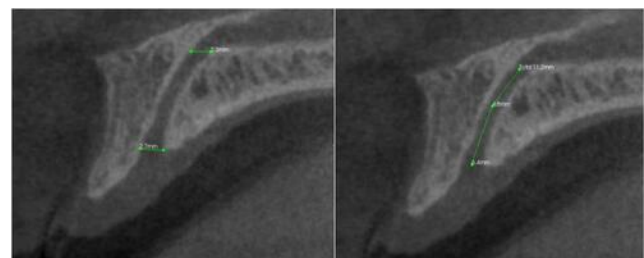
Sagittal section of the CBCT scan showing the length of the canal using the polyline tool and the width of the canal using the single measure tool at the nasal and the oral openings.
